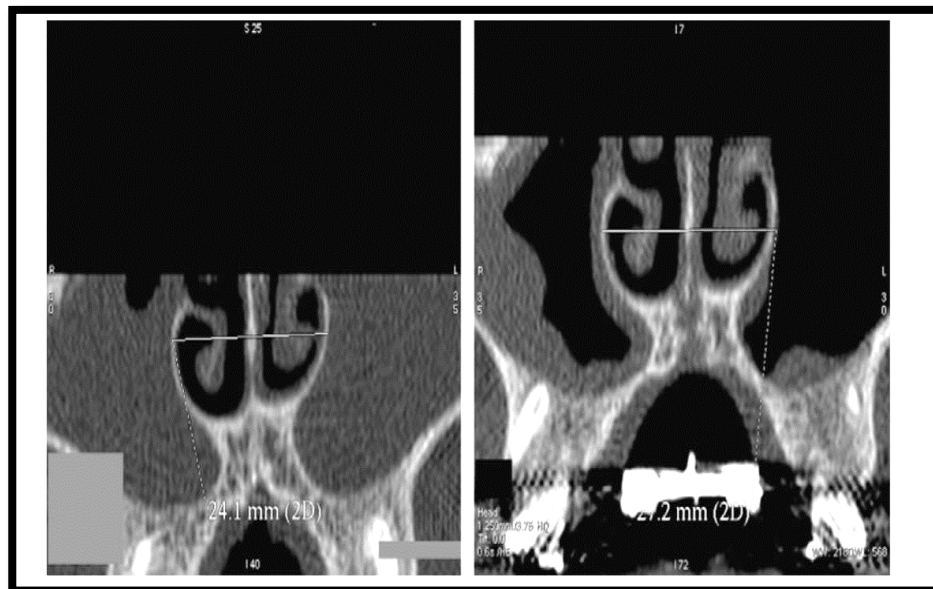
CT Dentascan of nasal cavity increase before and after RMA (Christian, 2010)
